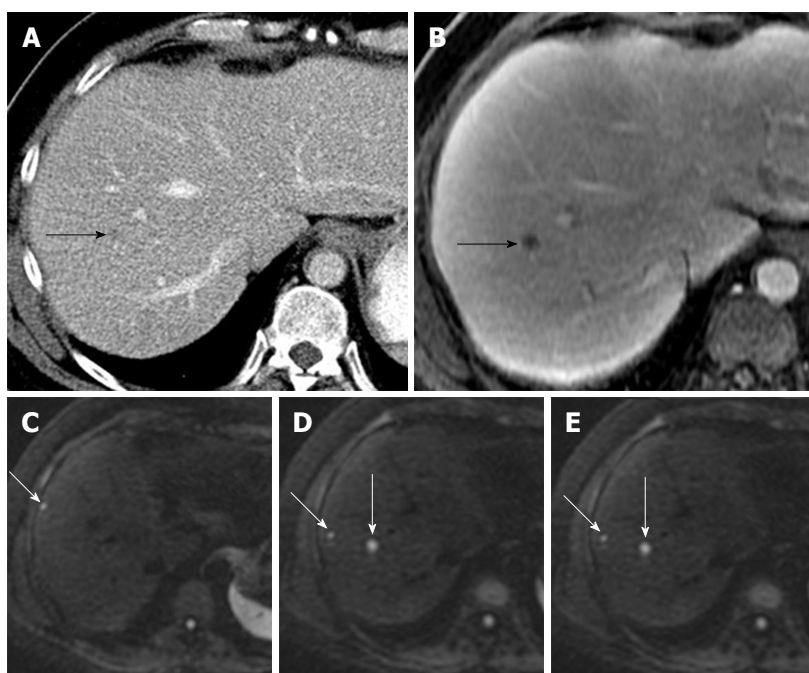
Value of diffusion-weighted magnetic resonance imaging in lesion detection in a 51-year-old male with metastatic leiomyosarcoma of the thigh. A: Axial contrast enhanced CT scan demonstrated a subtle hypodensity in the right lobe of liver (black arrow); B: Axial post gadolinium T1-weighted MR image demonstrates a single metastatic lesion (black arrow); C-E: DW-MR image at b=600 demonstrates additional lesions (white arrows). DW-MR: Diffusion-weighted magnetic resonance; CT: Computed tomography.
